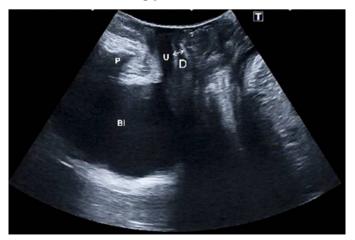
The ultrasound parameters P: Symphysis pubis, U: Urethra, BL: Bladder, D: Urethra mesh between distance
